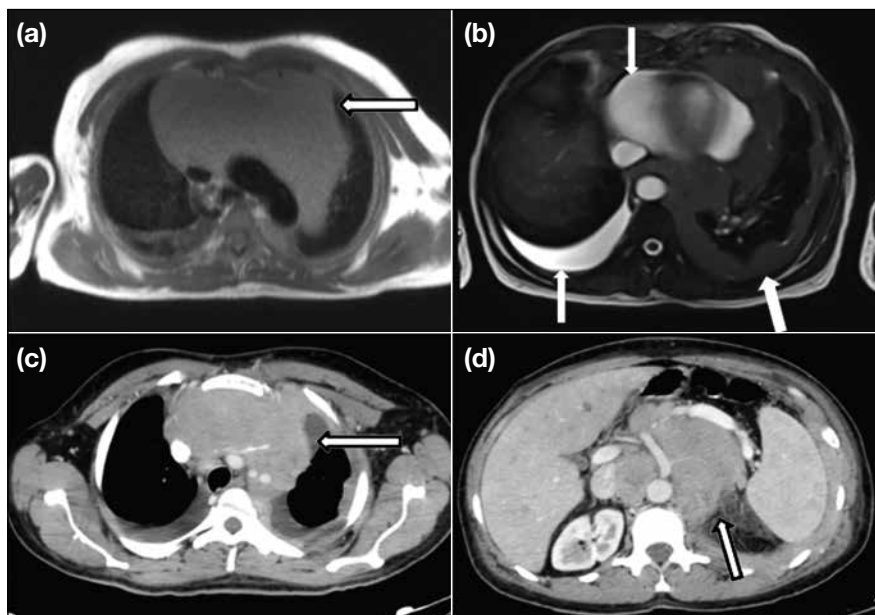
A 36-year-old male with B-cell lymphoma. (a) Axial black-blood cardiovascular magnetic resonance imaging showing a large anterior mediastinal mass surrounding and displacing the great vessels (arrow). (b) True fast imaging with steady-state free precession magnetic resonance imaging axial image showing lobulated soft tissue thickening of the left pleural cavity with pericardial and right pleural effusion (arrows). (c) Axial computed tomography (CT) image at the level of the chest confirms the findings in (a) [arrow]. (d) Axial CT image at the abdomen shows prominent paraaortic lymphadenopathy (arrow).
